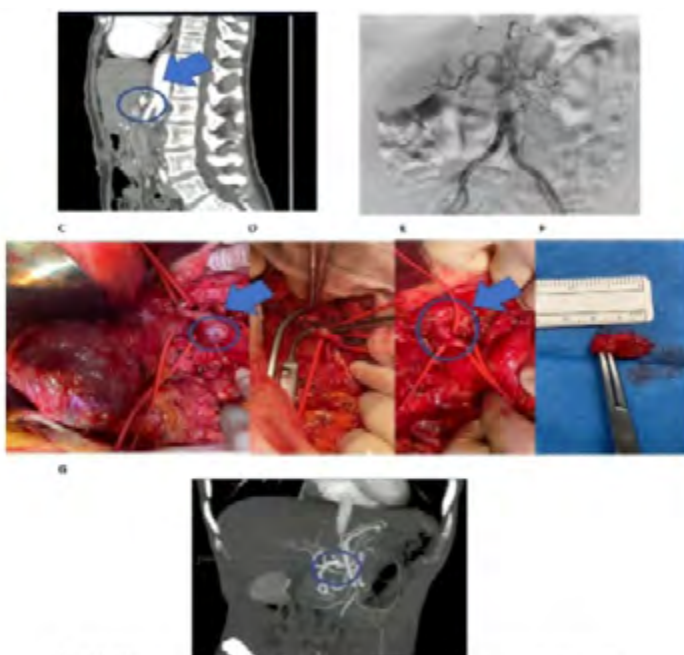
A) CT showing the location of arterial shunt; B) Fluoroscopic image showing common hepatic artery during angiography with catheter in inferior mesenteric artery; C) Angiogram of the common hepatic artery with proximal and distal control using red and yellow slings; D) Angiogram showing resection of common hepatic artery to essential mesenteric artery; E) Thrombosed aneurysm; F) Control angio-CT showing thrombosed aneurysm
